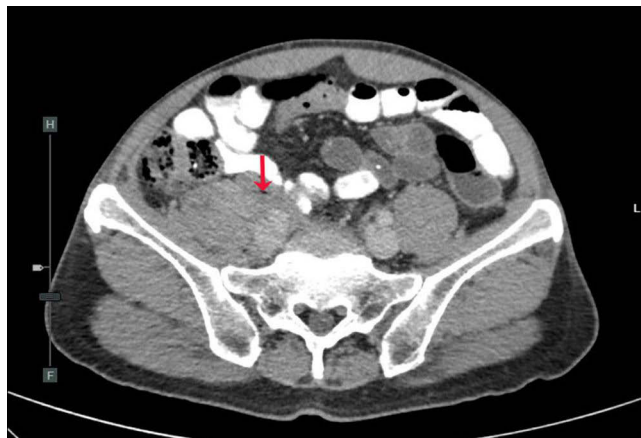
Computed tomography (CT) scan of chest and whole abdomen demonstrating infiltrative soft-tissue mass surrounding the periaortic and aortocaval regions with extension to involve the right psoas muscle (red arrow).
